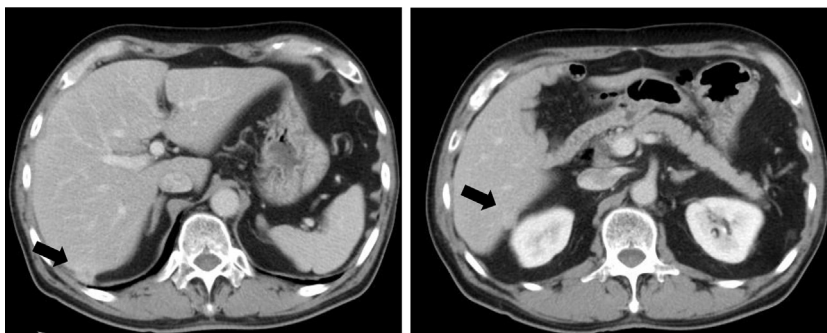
a and b. Preoperative abdominal CT findings. Abdominal CT revealed two irregular peripherally enhanced S6 tumors protruding from the liver surface (black arrow). CT, computed tomography.
